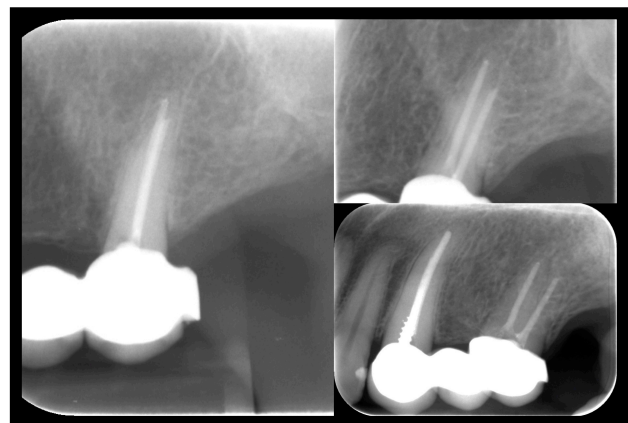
Radiographic history, Left: Jan 2011; Right: Mar 2011
